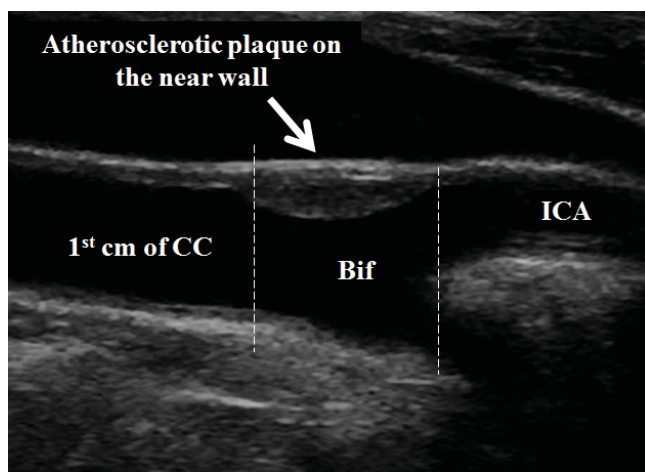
Ultrasound image of an extracranial carotid with an atherosclerotic lesion in the near wall of bifurcation. If only C-IMT of the far wall of the common carotid artery is considered, this patient would be classified as normal.
